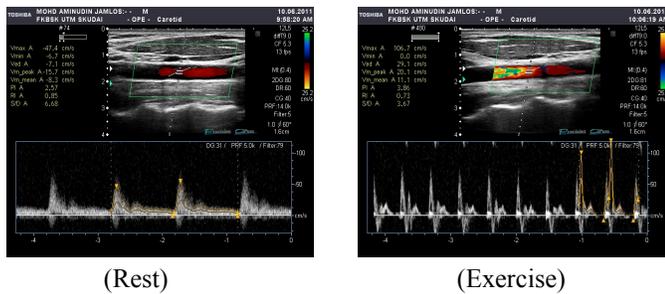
Doppler ultrasound carotid artery images during rest and exercise
